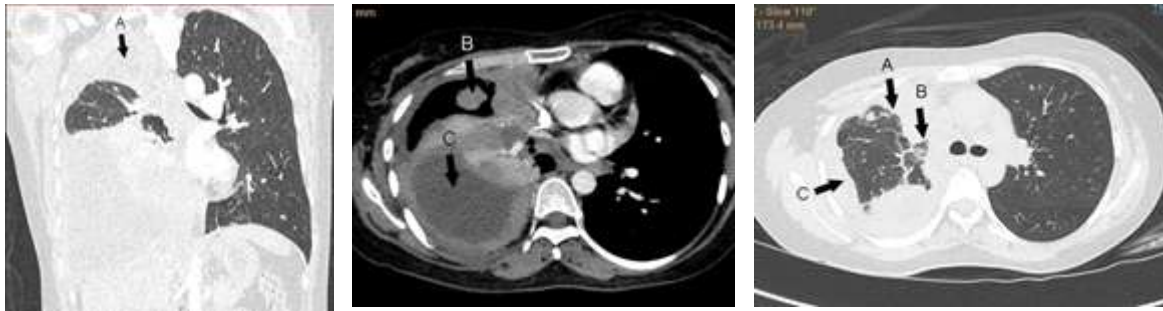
CT scan of the second patient, found tuberculosis lung (A), nodule / mass in lung right (B), right pleural effusion (C).
